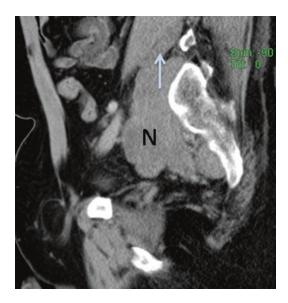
Contrast-enhanced CT sagittal image identifies lobulated growth of lesions (N) medial to the right iliac bone, with a clear demarcation, and slightly heterogeneous enhancement. The strip-like shadow at the inferior margin of the lesion is thickened nerve root within the right foramen between the L5-S1 vertebra (\uparrow). The inferior portion of the nerve root merges into the lesions medial to the right iliac bone. The posterior portion of the lesion to the sacral vertebrae but does not infringe the sacrum
